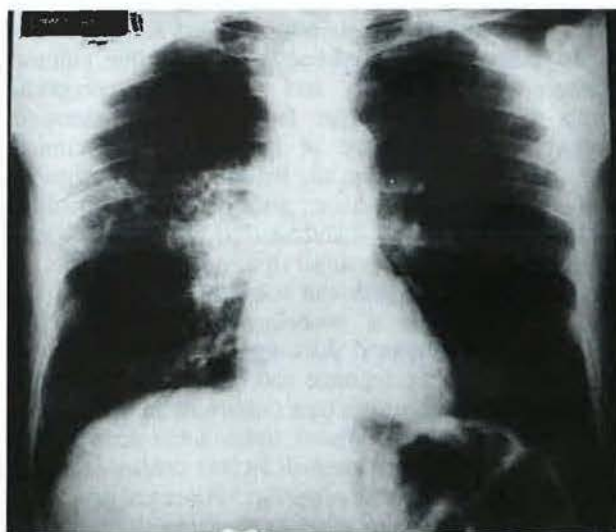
Chest roentgenogram on admission showing an alveolar pattern with microcavitation on the right upper lobe suggesting necrotizing pneumonia.
